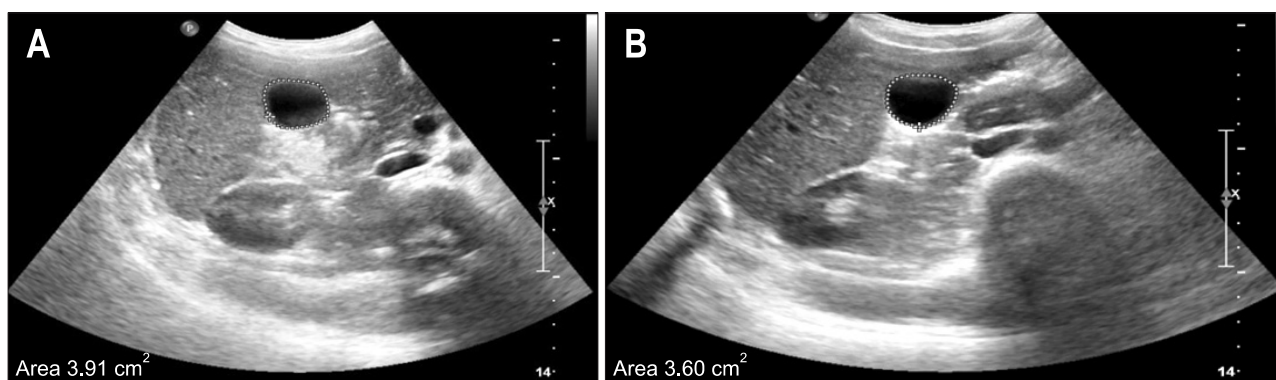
Region-of-interest indicates the gallbladder cross-sectional area. Preprandial (A) and postprandial (B) ultrasounds in a 3-year-old child with constipation. The contractility index (CI) was 7.6% (CI, <25%).
